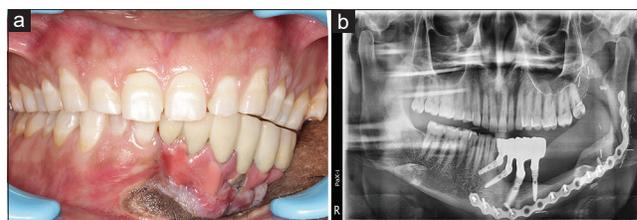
(a) Intraoral view after a 3-year follow-up. (b) Postoperative orthopantomogram after 3-year follow-up
